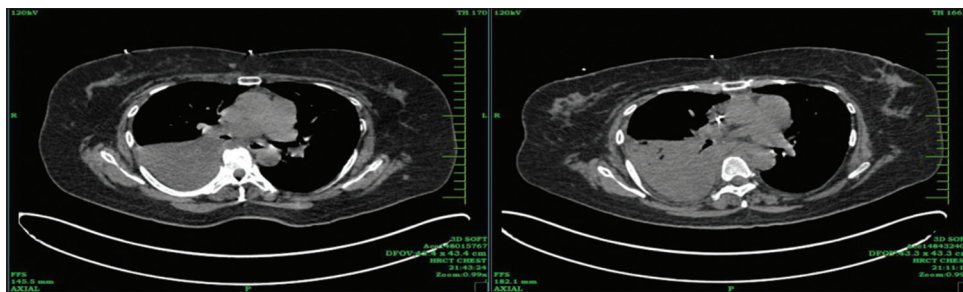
High-resolution computed tomography CHEST performed on admission demonstrating consolidation in lower zone of right lung
